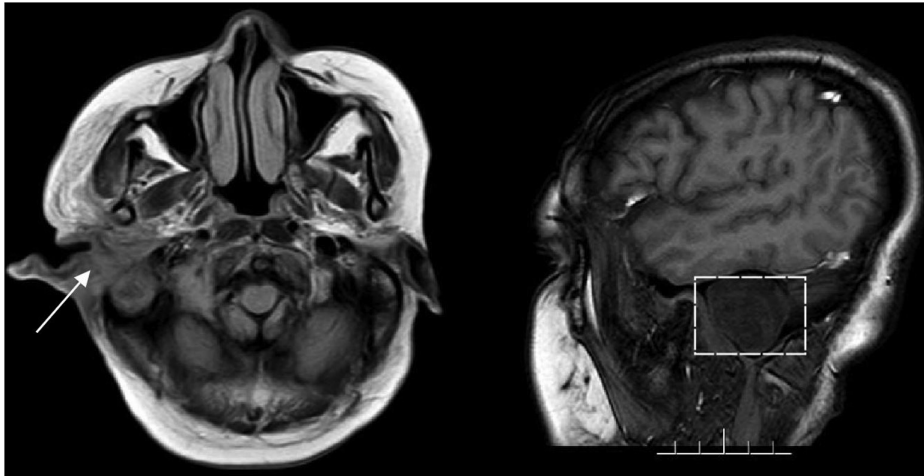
MRI displayed a right middle ear mass with a high mixed signal.
